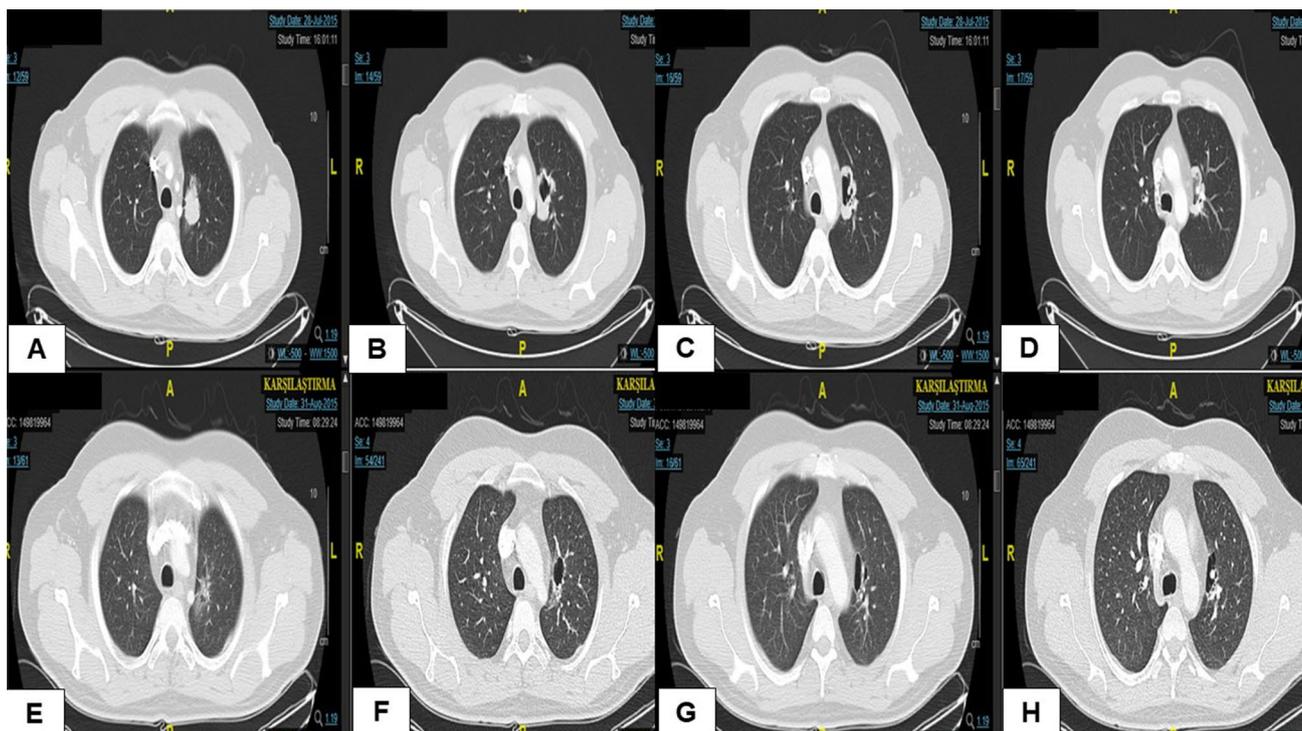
Computed tomography imaging at the baseline (a, b, c, d) and after 4 weeks of crizotinib therapy (e, f, g, h)
